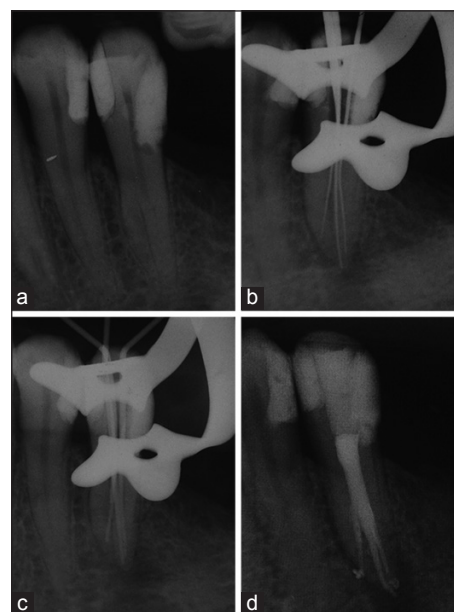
(a) Preoperative radiograph. (b) Working length radiograph. (c) Master cone IOPAR. (d) Obturation radiograph
